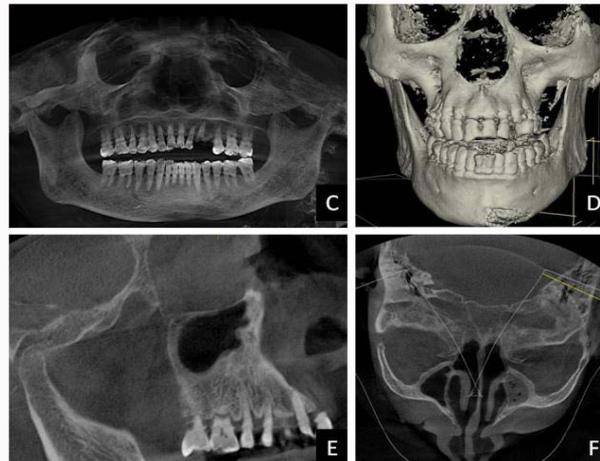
Panorama, 3-D, tangential and axial sections of Cone beam computed tomography reveals absence of bony changes in the region of interest and only radiopacity in the left maxillary sinus can be appreciated as an incidental finding.
